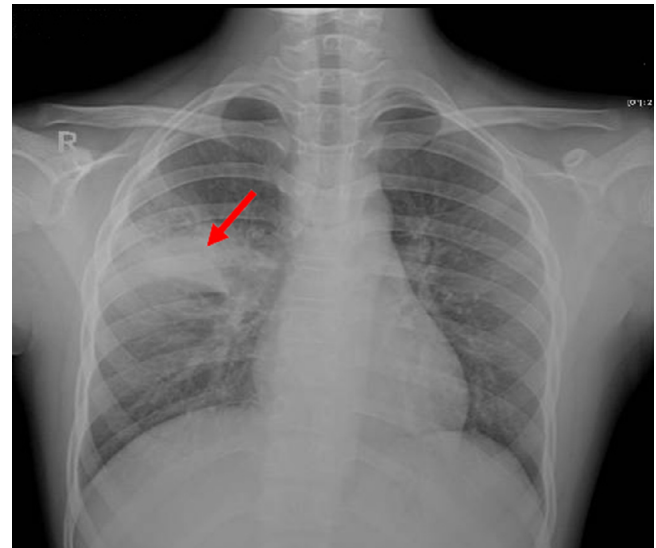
The initial chest radiograph showed an opacity in the right middle zone (arrow)
